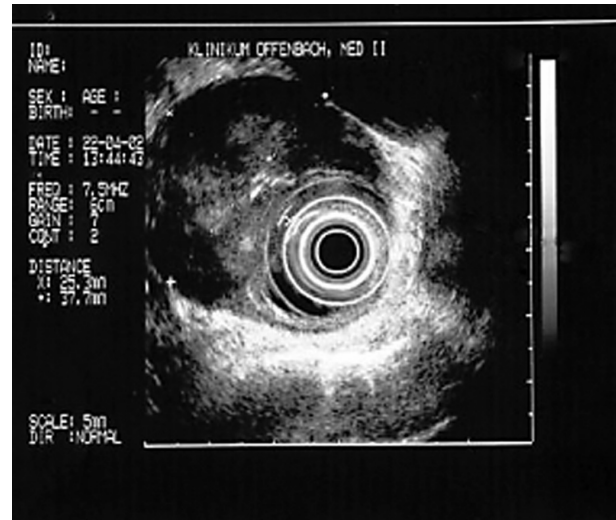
Endosonographic imaging for assessment of tumour staging
